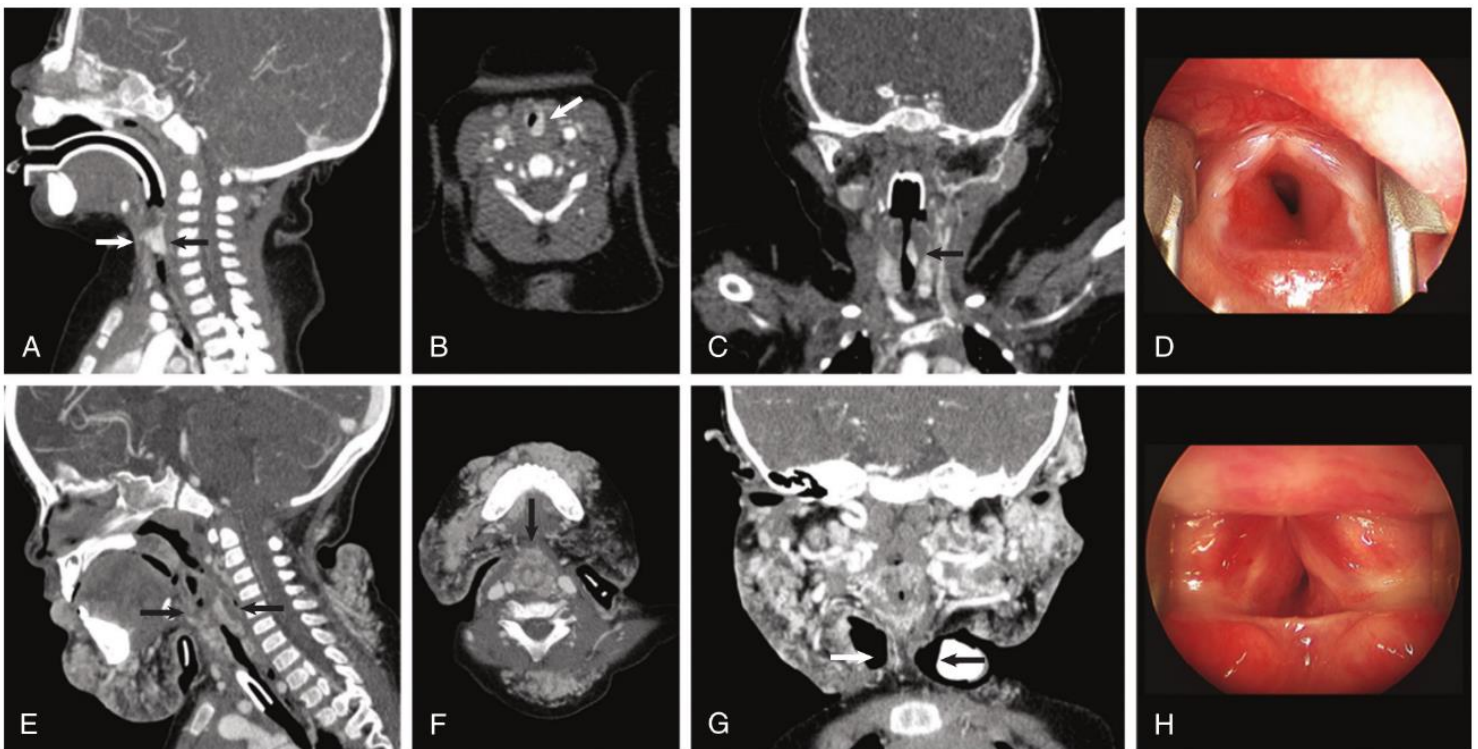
Computed tomography (CT) and endoscopic assessment of airway hemangioma of infancy. A, to C, CT appearance of focal airway hemangioma of infancy in medial subglottis. A, Sagittal. B, Axial. C, Coronal. D, Unilateral posterior focal hemangioma; left subglottis, same patient. E to G, CT appearance of segmental airway hemangioma of infancy. H, Circumferential, segmental hemangioma; subglottis, same patient.
